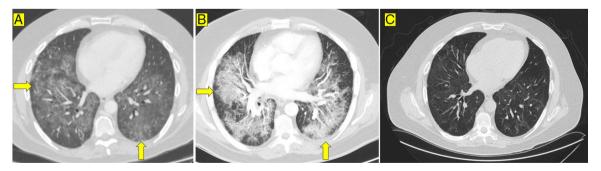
Chest CT scan. Radiological images of interstitial lung disease.
